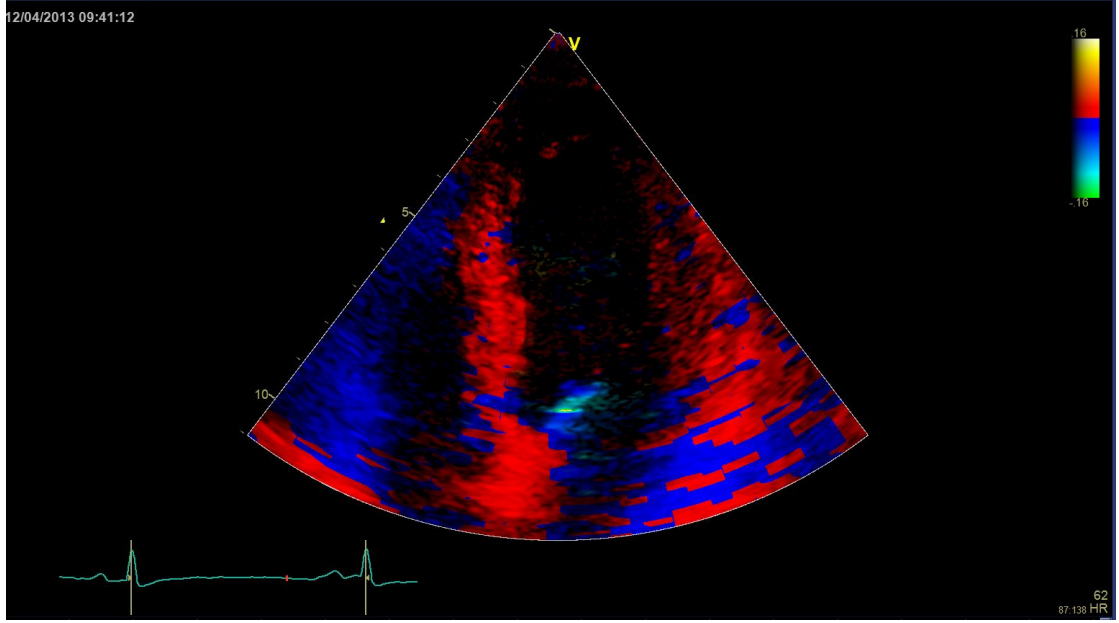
Tissue Doppler data superimposed on a b-mode cine, 4-chamber apical view. Blue color represent movement away from probe, while red represents movement towards the probe.
